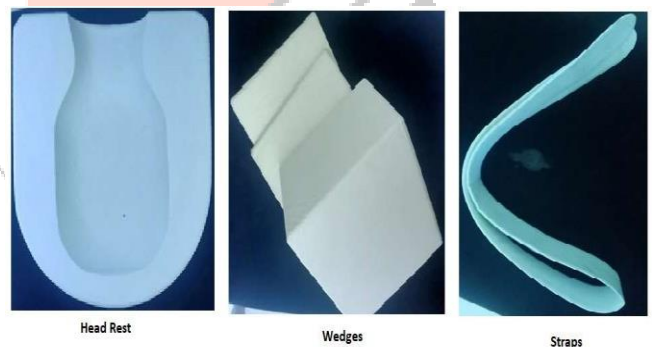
Immobilization devices used in MRI (Philips Multiva 1.5 Tesla) in the Department of Radiodiagnosis in Superspecialty Hospital. INSTRUMENTS FOR DATA COLLECTION
